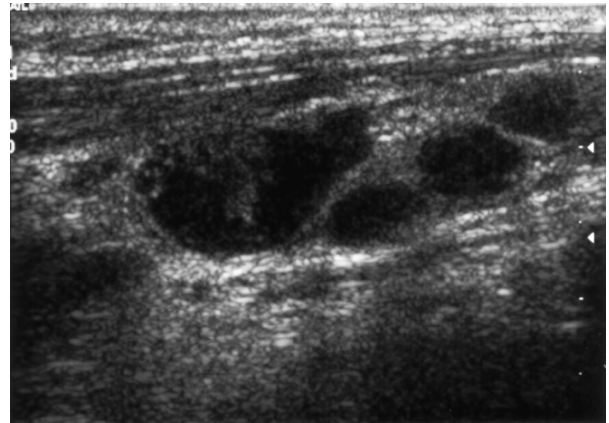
Longitudinal sonogram showing matting of multiple lymph nodes in the posterior triangle.
